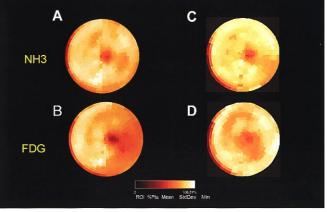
The ¹³N-NH₃ PET imaging showed no perfusion abnormality (A), but the ¹⁸F-FDG PET imaging showed reduced glucose uptake in the lateral wall (B) in the subacute phase. Both the NH₃ and ¹⁸F-FDG PET imaging showed normal uptake on 3-month follow up (C, D).
